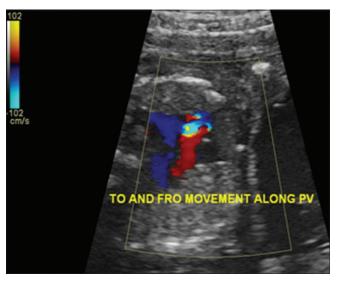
Color Doppler: To and fro movement along the pulmonary valve (PV) as a sign of stenosis and severe insufficiency
